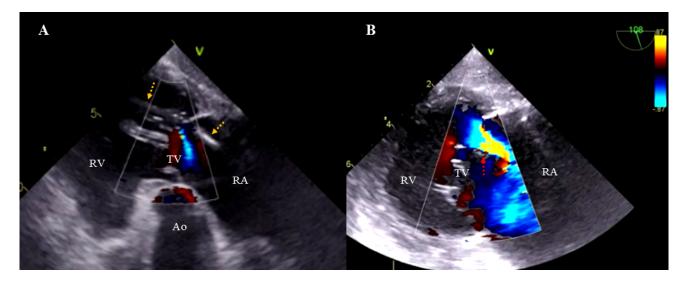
Tricuspid valve damage—rupture of the chordae tendineae. (A) Two-dimensional TEE, transgastric projection. Color Doppler. The ventricular lead (yellow arrows) adheres to the posterior leaflet and the sub-valvular apparatus. Mild tricuspid regurgitation, blood leaking backward into the right atrium. (B) Two-dimensional TEE transgastric projection, Color Doppler. Rupture of the chordae tendineae (red arrow) during ventricular lead extraction, worsening regurgitation to a higher grade. RA, right atrium; RV, right ventricle; TV, tricuspid valve; LA, left atrium; Ao, aorta; TEE, transesophageal echocardiography.
